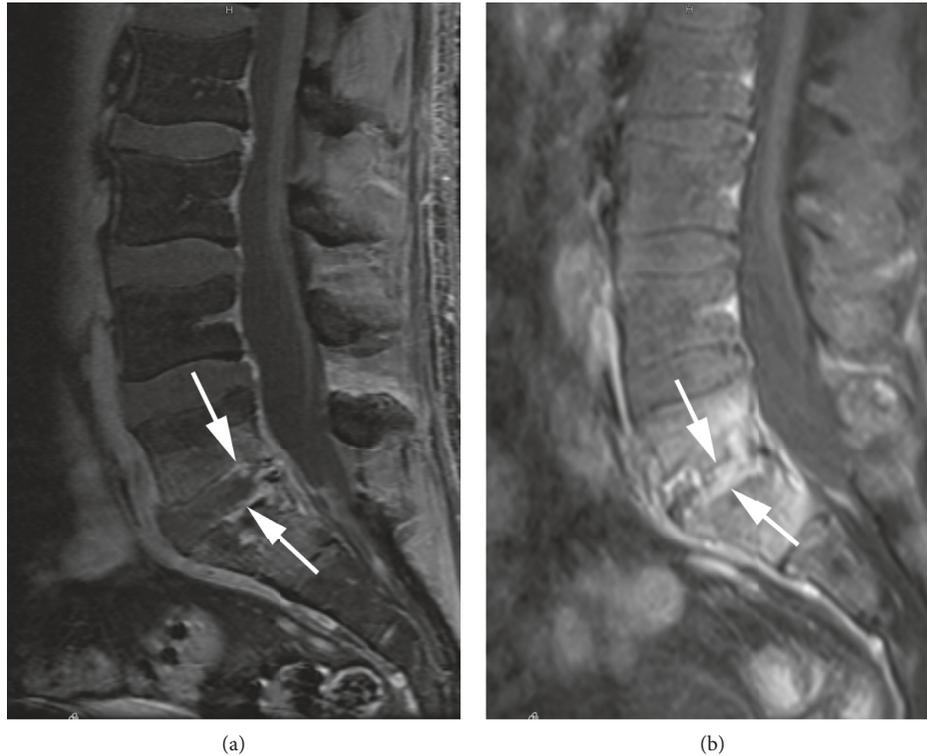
T1-weighted fat-suppressed lumbar spine MR images after contrast agent administration. (a) Initial MRI demonstrating spondylodiscitis L5/S1 with subtle contrast agent enhancement of both intervertebral disk L5/S1 and adjacent subchondral bone (arrows). (b) A follow-up MRI at 4 months showing progressive spondylodiscitis (arrows) without abscess formation.
